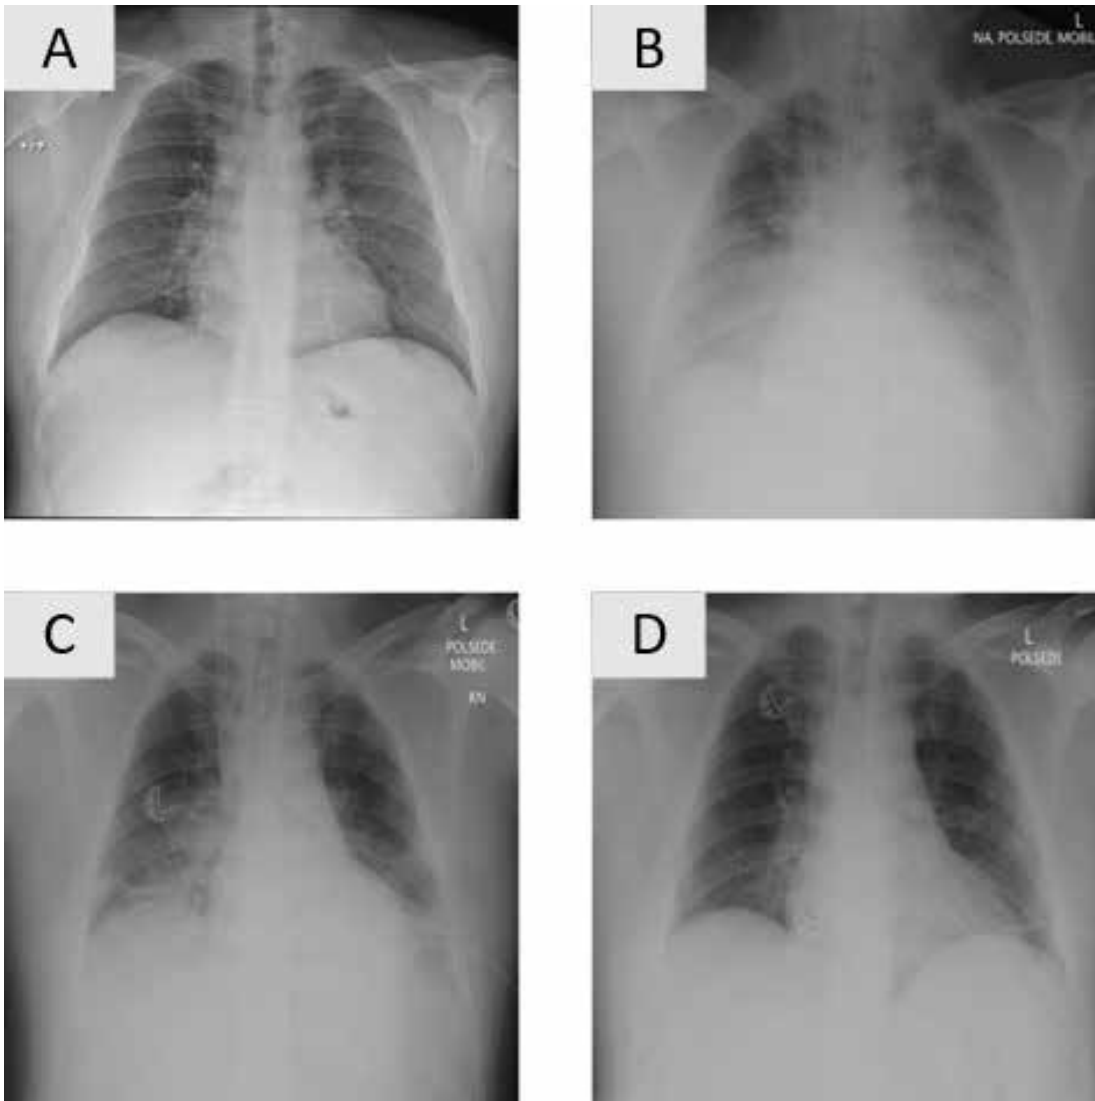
Chest X-ray at various times during treatment.
